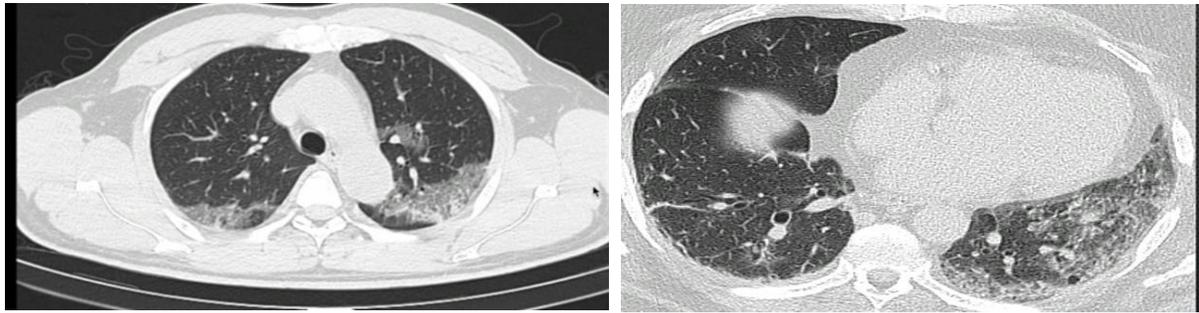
4: HRCT scan of chest (cross section) showing ground glass appearance, in concomitance with COVID infection.
